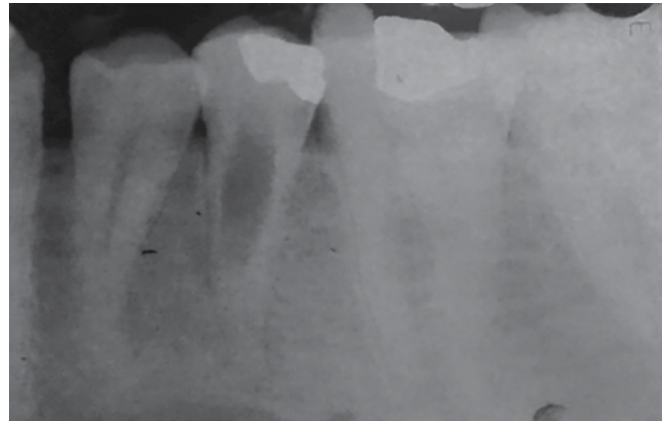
Intraoral periapical radiograph of mandibular second premolar reveals radiolucency below the amalgam restoration on the distal tooth surface, widened root canal space extending from the coronal to the middle third of the root with adjacent bone rarefaction
